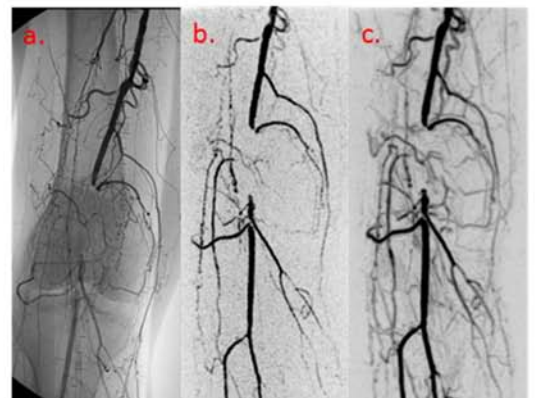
a) X-Ray DSA image of a patient showing occlusion of popliteal artery. b) IVD-HYCR MRA image. c) Conventional clinical view-shared MRA image.
